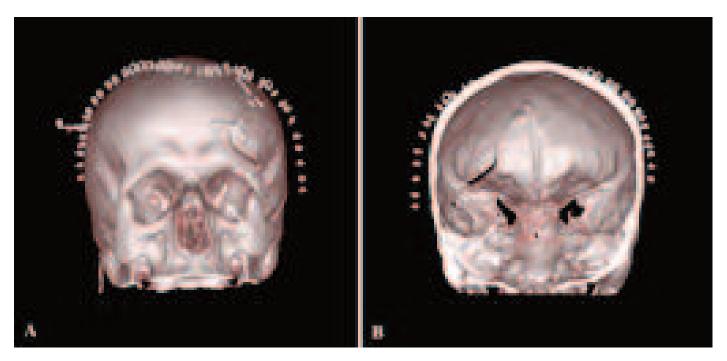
Postoperative 3D CT scans. A. Anterior (arrow) and B. posterior view of the reduced fracture lines and decompressed superior orbital fissure (arrow). 3D CT=three-dimensional computed tomography.
